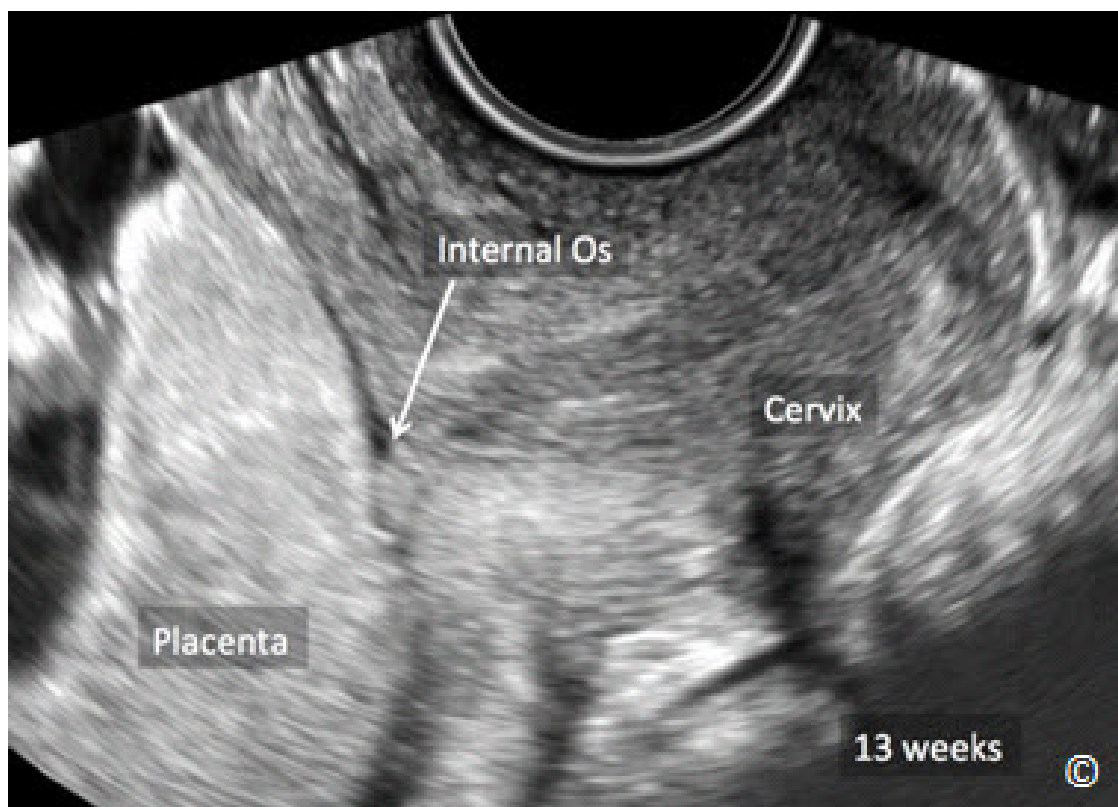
Ultrasound of an intrauterine pregnancy at 13 weeks. Note that the placenta (labeled) is covering the internal os of the cervix (labeled), representing a placenta previa.
